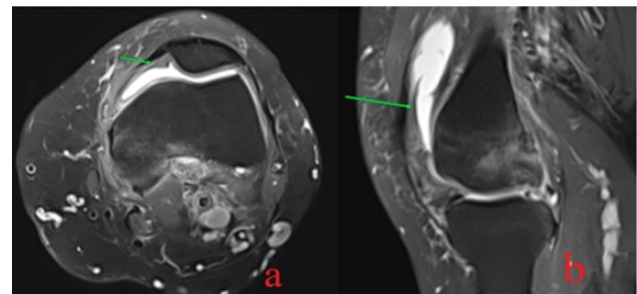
MRI before PRP injection, (a) Axial T2WI and (b) Sagittal STIR revealed diffuse uniform synovial thickening suggestive of synovitis.
